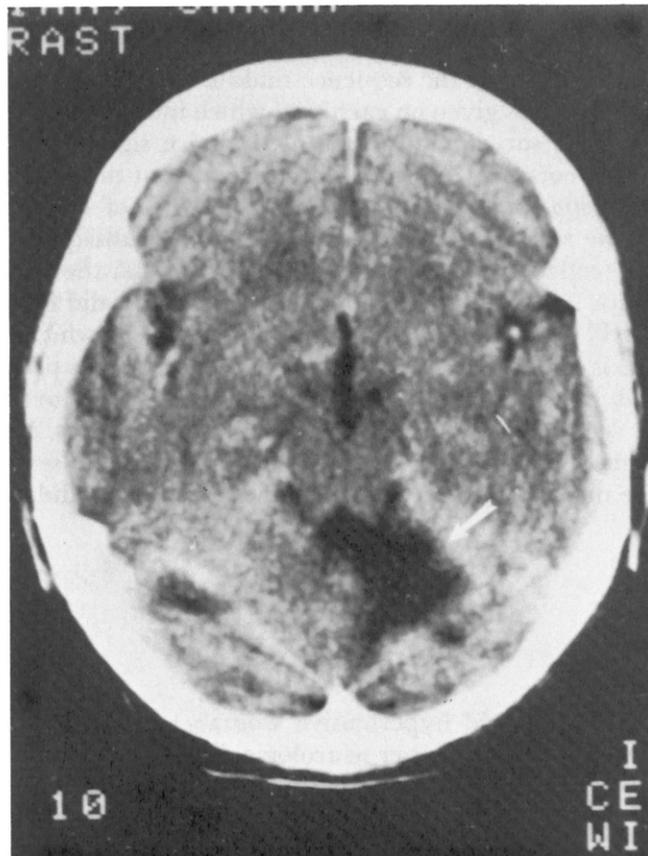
CT scan of patient CG. Note the infarcted medial cerebellar structure.
